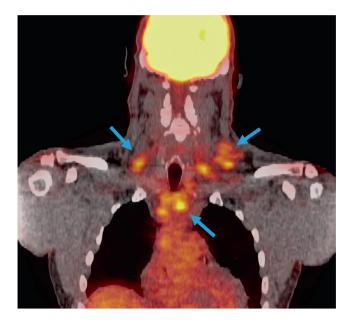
Positron emission tomography showing FDG avid (blue arrows) left lower neck, bilateral supraclavicular, and upper mediastinal lymph nodes.
